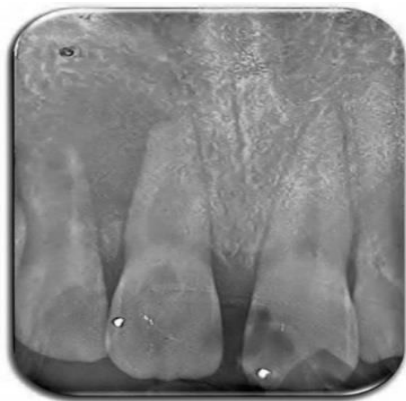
Preoperative radiograph with enlargement of the root canal space suggesting internal root resorption in tooth 11 and a periradicular lesion. Tooth 12 presented a wide canal and a short root with thin radicular dentin walls
